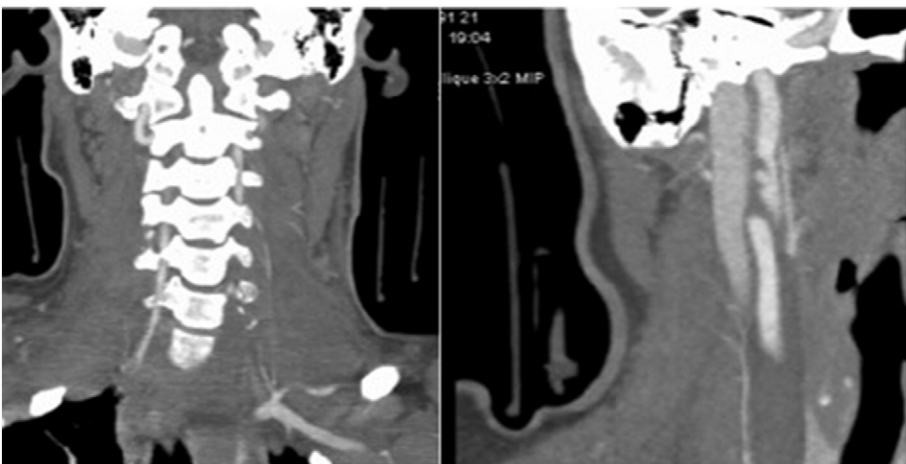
CTA of the neck demonstrates a fracture of the C6 left transverse process with an associated loss of opacification of the left vertebral artery at the levels of C4–C7 (left). There is an intimal flap with a small 4 mm pseudoaneurysm in the distal right cervical internal carotid artery (right).
